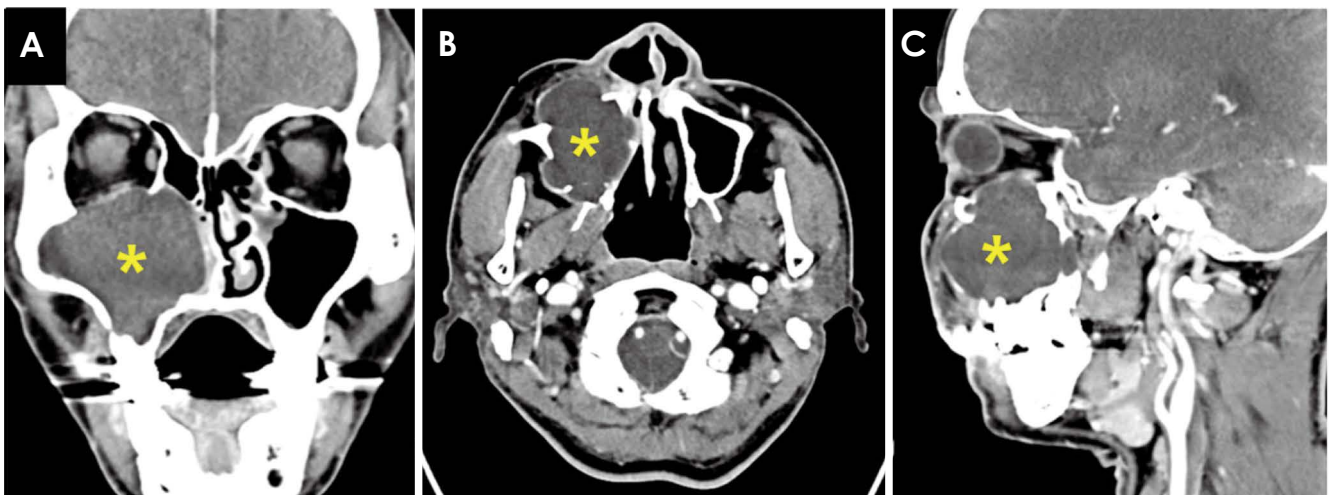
A. An enhanced computed tomographic coronal image shows a spherical, unilocular, expansile lesion (asterisk) in the right maxillary sinus, elevation and thinning of the orbital floor, and displacement of the orbital contents. B. An axial image shows bony erosion and remodeling of the surrounding walls. Contrast enhancement is not observed. C. A sagittal image shows expansion of surrounding walls and elevation of the orbital floor.
